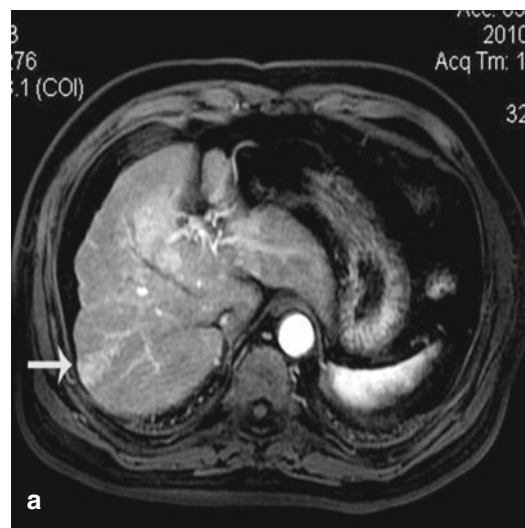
Images in a 58-year-old male with a 2.0×1.5 cm lesion in segment VII of the liver. (a) Contrast-enhanced MRI shows a hyper-vascular tumor (arrows) in segment VII of the liver. (b) Conventional US could not detect the lesion. (c) US images and MR images were synchronized using the internal markers at the best timing of the inspiration. (d) MW antenna was inserted into the tumor under real-time virtual navigation system guidance. (e) Contrast-enhanced MRI obtained 1 month after MW ablation shows complete necrosis of the tumor (arrows)
